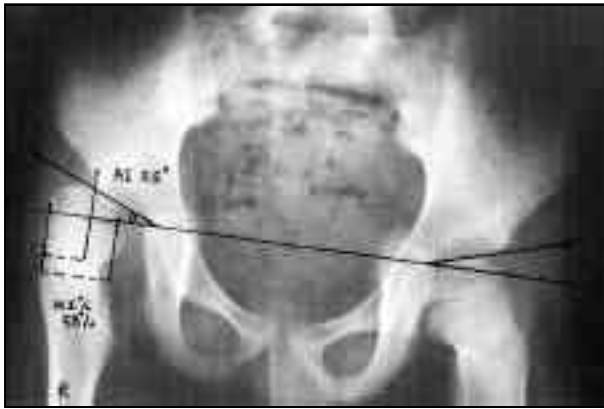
Case No. 17, Preoperative X-ray showing right hip subluxation
